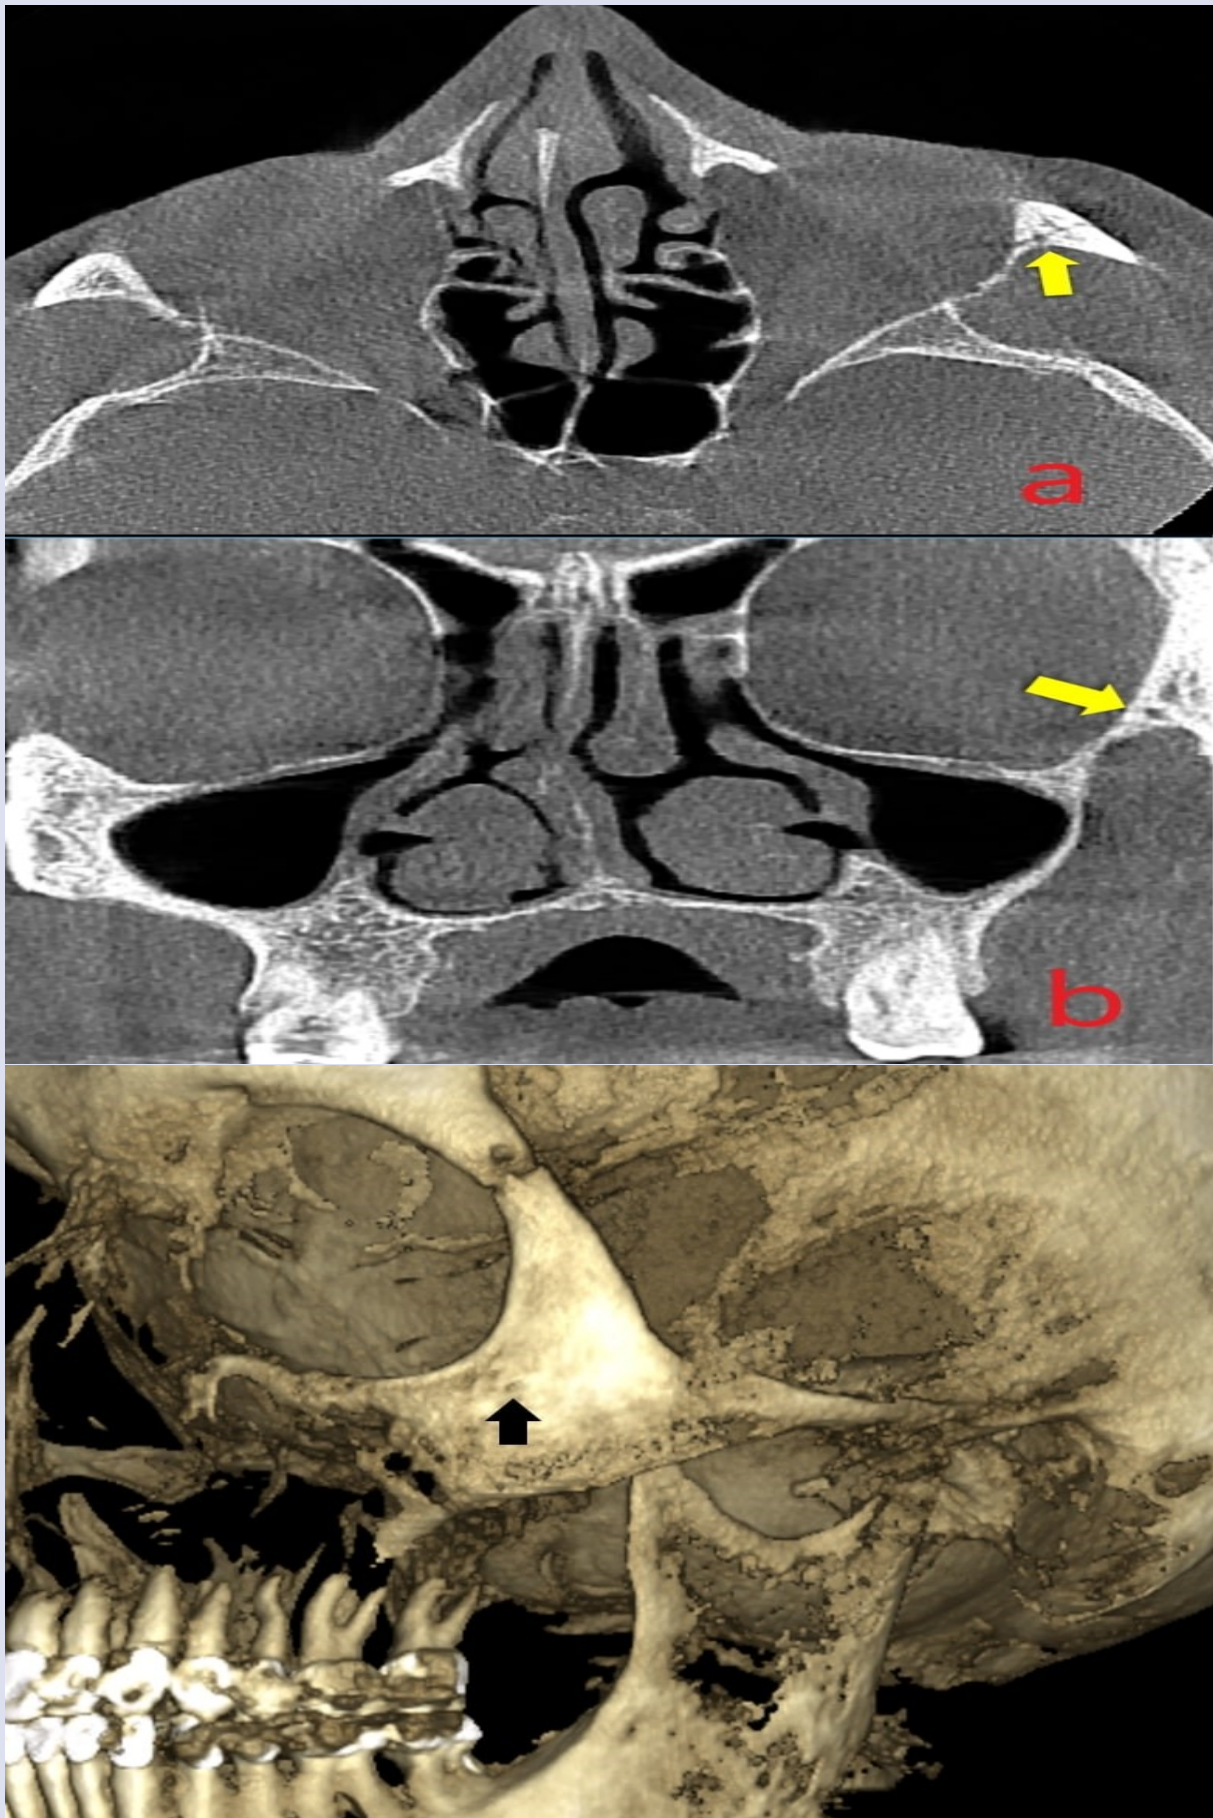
Zygomaticofacial Canal in CBCT: a) axial section (indicated by yellow arrow) and b) coronal section (indicated by yellow arrow).
